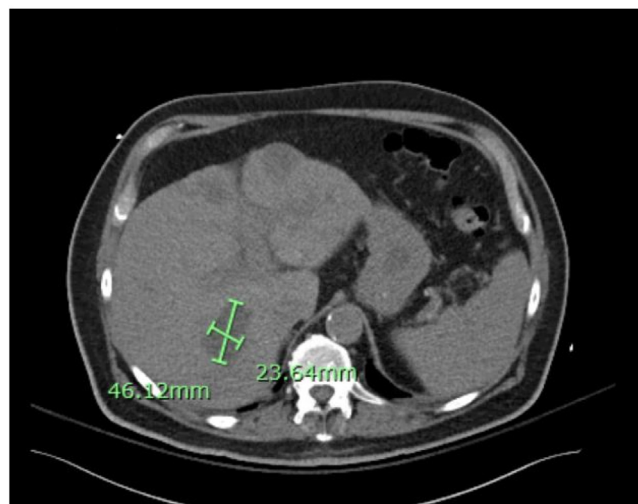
Contrast CT of the abdomen showing a second liver collection with dimensions noted.
